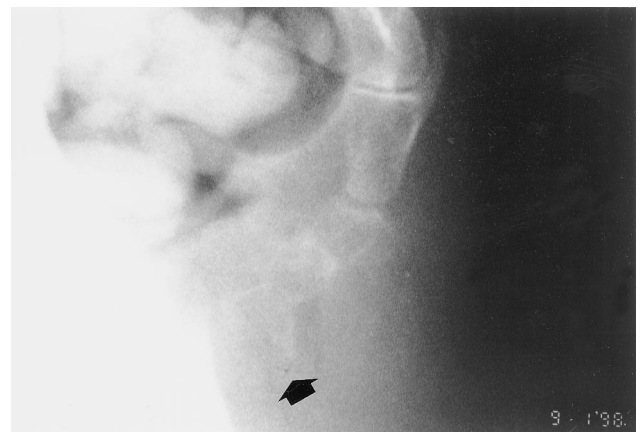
Coccygeal spicule on the dorsal aspect of the tip of the coccyx. It is difficult to detect, even on good-quality radiographs, which explains why it has not been described earlier.
